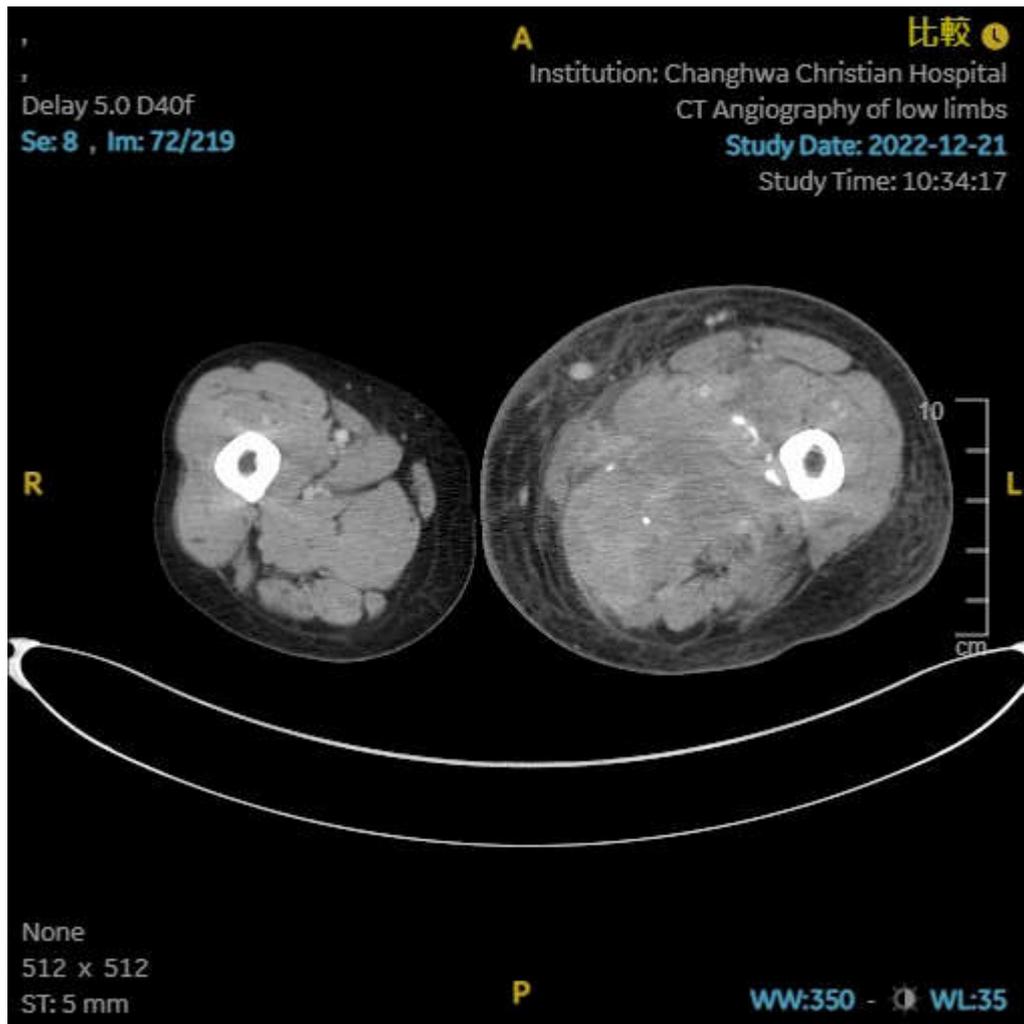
Abdominal computed tomography revealed diffuse calcification and area of low density in the left thigh muscle. (2) Coronal view (3) Transverse view.
